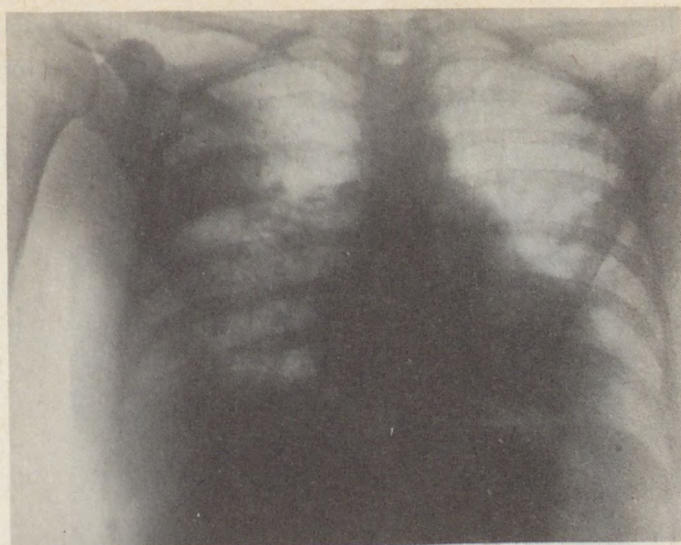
Thoracic X-ray picture of H.J. (case 1) on admission
